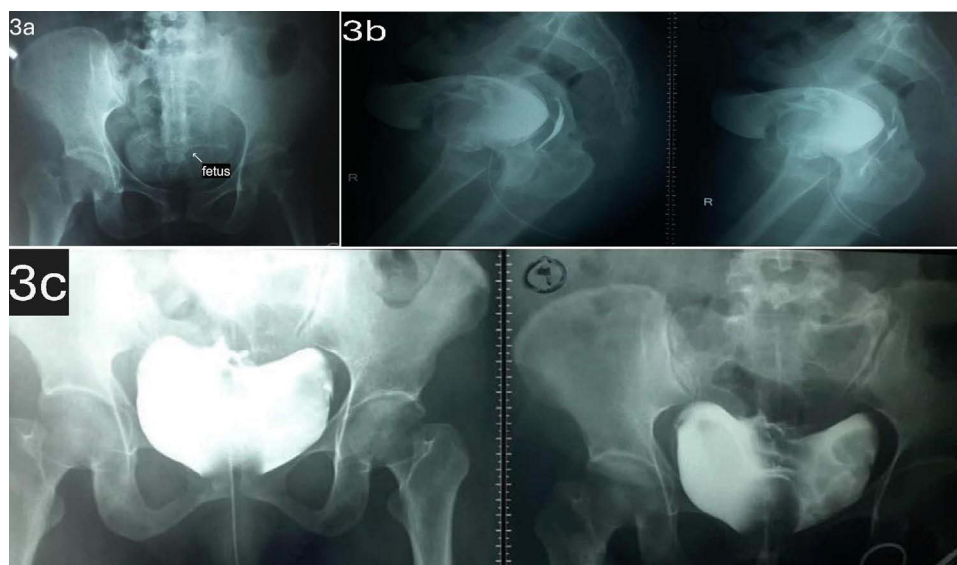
Cystography revealed a dead fetus in the vesica urinaria and the cranial vesica surface of the urinary bladder appears. (a) Plain pelvic X-ray; (b) lateral view with contrast; and (c) anteroposterior view with contrast.
